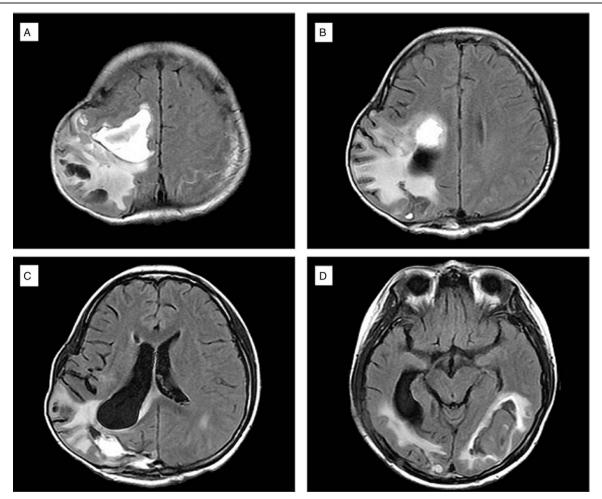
After 6 instances of hemorrhage in 4 lesions, head magnetic resonance imaging showed multiple intracerebral hemorrhage.
